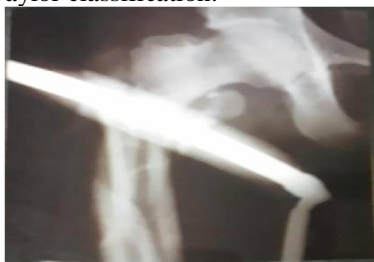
Pre op Xray of right subtrochanteric Femur Fracture
